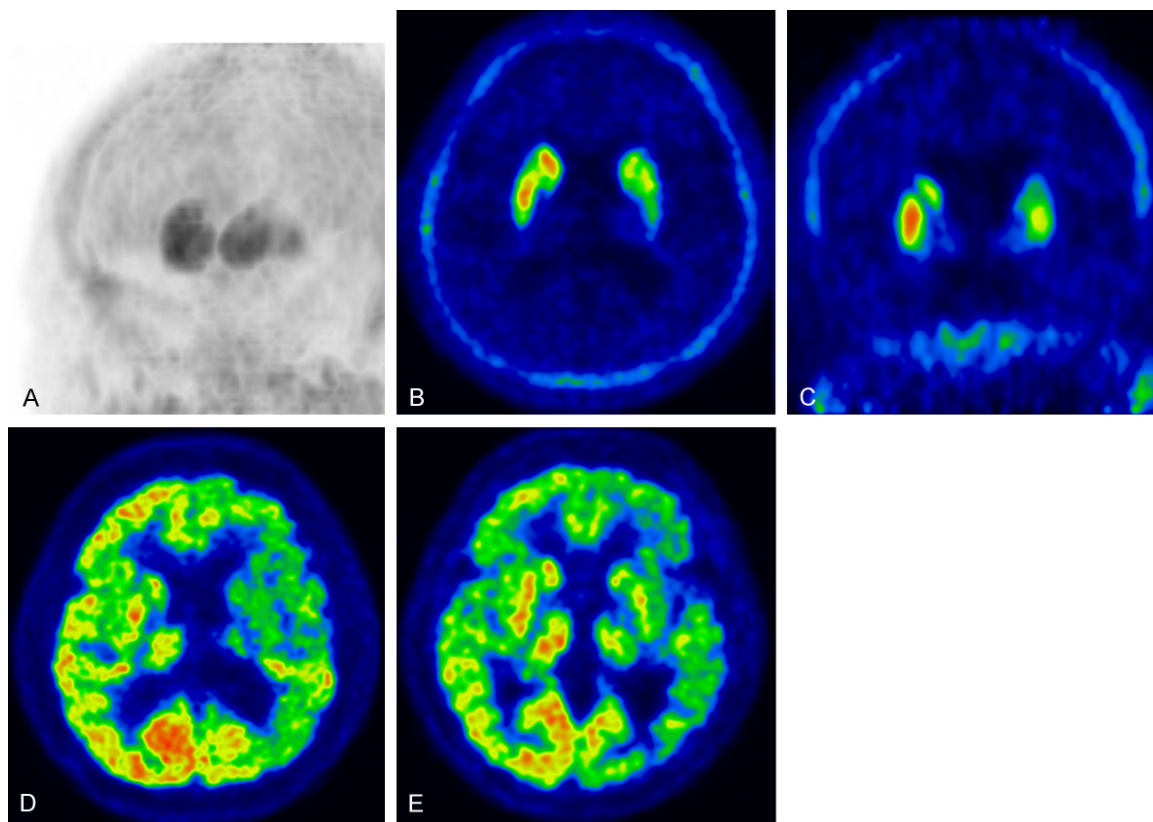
Corticobasal degeneration (CBD) (A) Maximum intensity projection image of DAT imaging using ^{18}F -FP-CIT showing prominent asymmetry of the striatum. (B) Transaxial and (C) coronal DAT images showing decreased tracer uptake in the left caudate nucleus and putamen. (D) Early perfusion image of ^{18}F -FP-CIT and (E) glucose metabolism of ^{18}F -FDG showing decreased perfusion and glucose hypometabolism in the left cerebral hemisphere, striatum, and thalamus.
